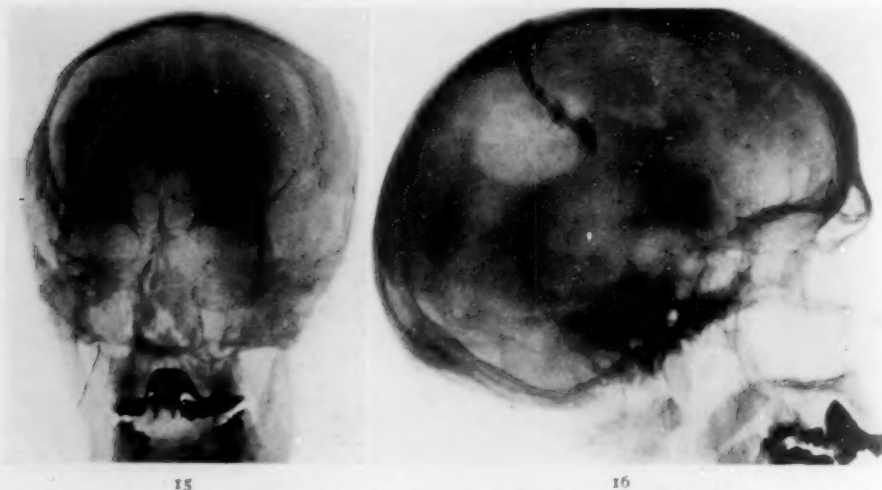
Antero-posterior view without any sodium iodide injection. This and the preceding plate were made twenty-eight days after radiographs, Figs. 12 and 13, and after the patient had had an exacerbation of his old symptoms.
